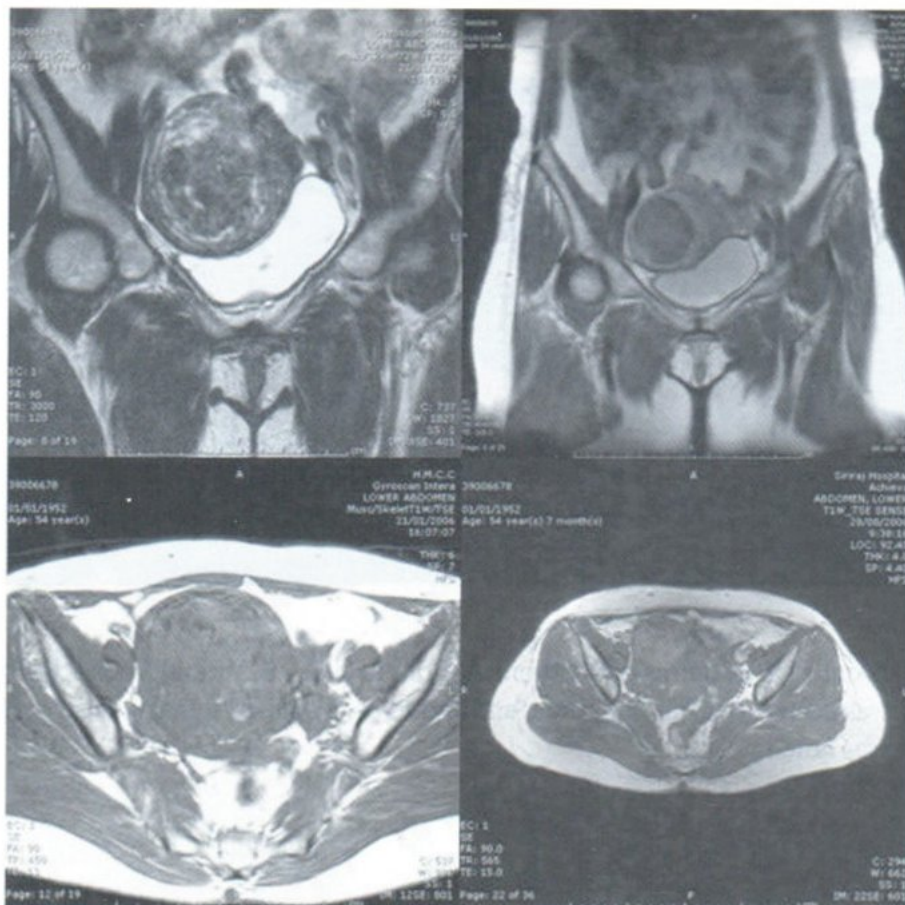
Coronal and axial MRI images in pre-UAE (A,B) and 1 month post-UAE (C,D) Post-UAE images revealed significant decreased size of fibroid with hemorrhagic infarction.
